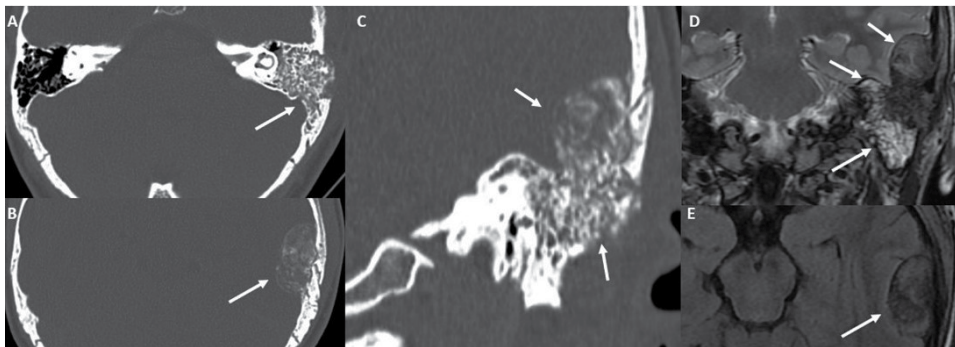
Osteoblastoma: CT Head axial (A, B) and coronal (C) images in the bone window reveal a circumscribed, expansile, heterogeneous mixed lytic and sclerotic lesion (white arrows) involving the mastoid part of the left temporal bone and has an extradural intracranial component superiorly. Coronal T2-weighted image (D) of the brain at the level of mass (white arrows) reveals heterogeneous increased T2 signal of the well-circumscribed mass. Osteoblastoma (white arrow) shows an iso-to-hypointense T1 signal (E).
